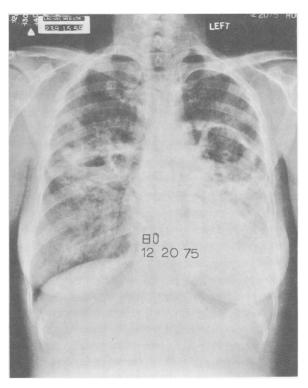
Posteroanterior chest roentgenogram showing diffuse interstitial infiltration with multiple cavities in both lungs, two with air-fluid levels.
